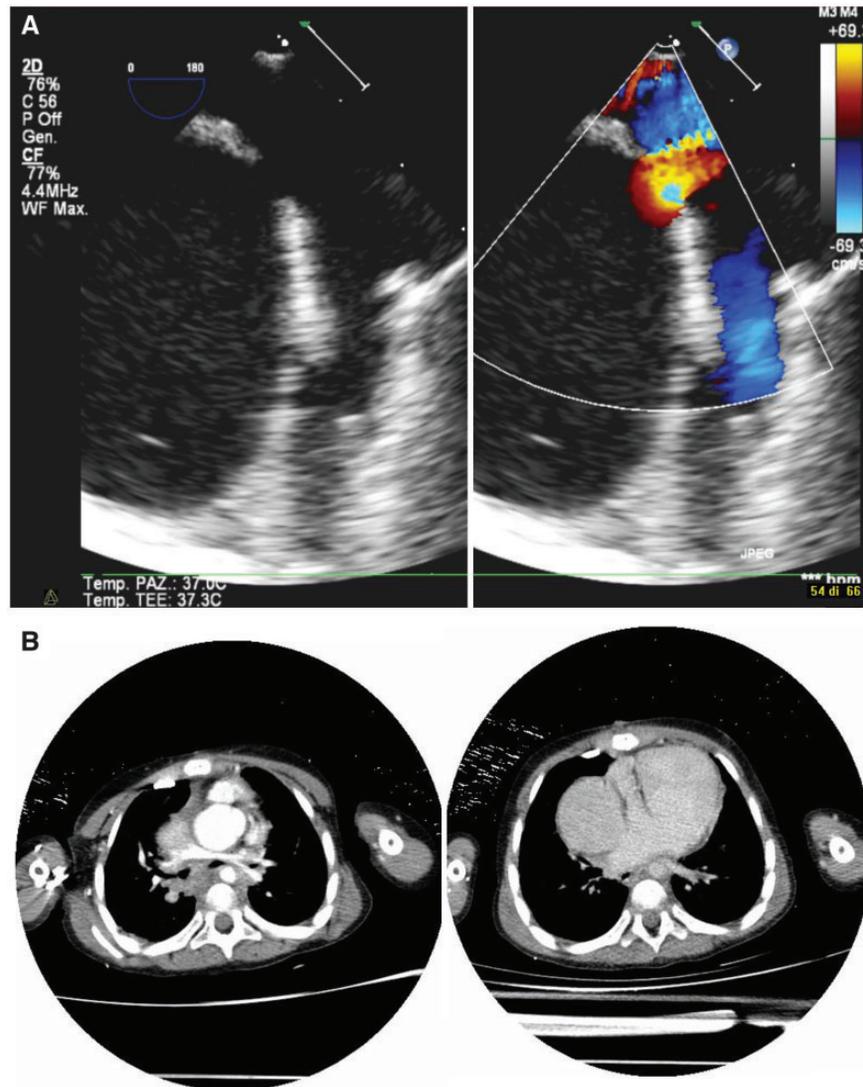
(A) Transoesophageal echocardiography showing a dilated fenestration. (B) Computed tomography showing the right pulmonary artery and dilation of the extracardiac Fontan circuit.
